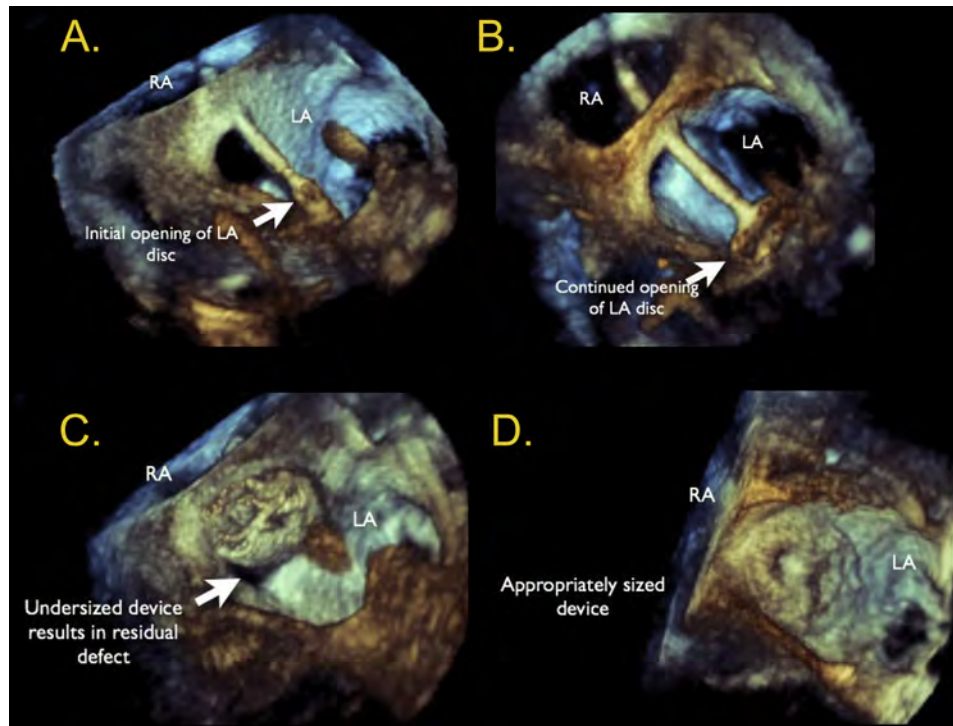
Intraprocedural RT3D TEE provides superior visualization of wires, catheters, and devices and their relationships to neighboring structures in a format that is generally more intuitively comprehended by the interventional cardiologist than 2D echocardiography. An ostium secundum ASD has been closed with an Amplatzer device under RT3D TEE guidance. All views are shown from the LA perspective. (A) The LA disc of the device opening in the LA. (B) View showing continued opening of the device. (C) An undersized device with a residual defect. This device was removed and (D) a larger closure device used.
